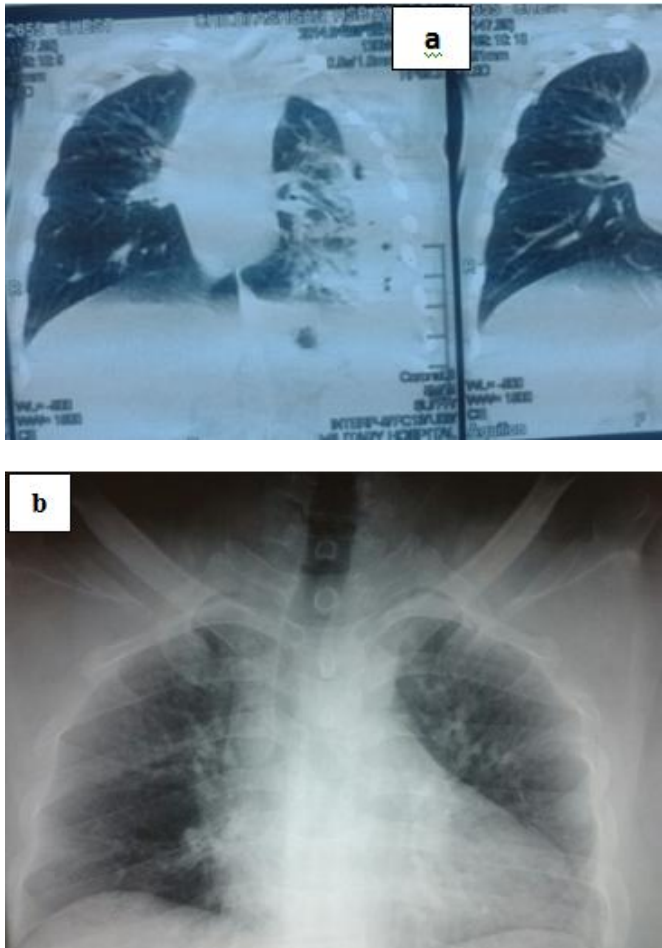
CT image showing (a) Lt Lingual and lower lobes consolidation, Lt obvious Emphysema thoraces, and fracture Lt 6th. Rib posterior, (b) CXR shows mild pneumothorax in the left side, multiple left posterior 3rd., 4th., 6th. and 8th. ribs fracture
